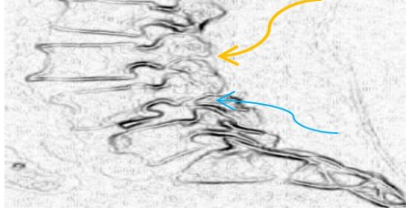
There are 4 different pseudo-bulging patterns that we have identified. The sagittal images below were revealed by filtering real MRI images.
